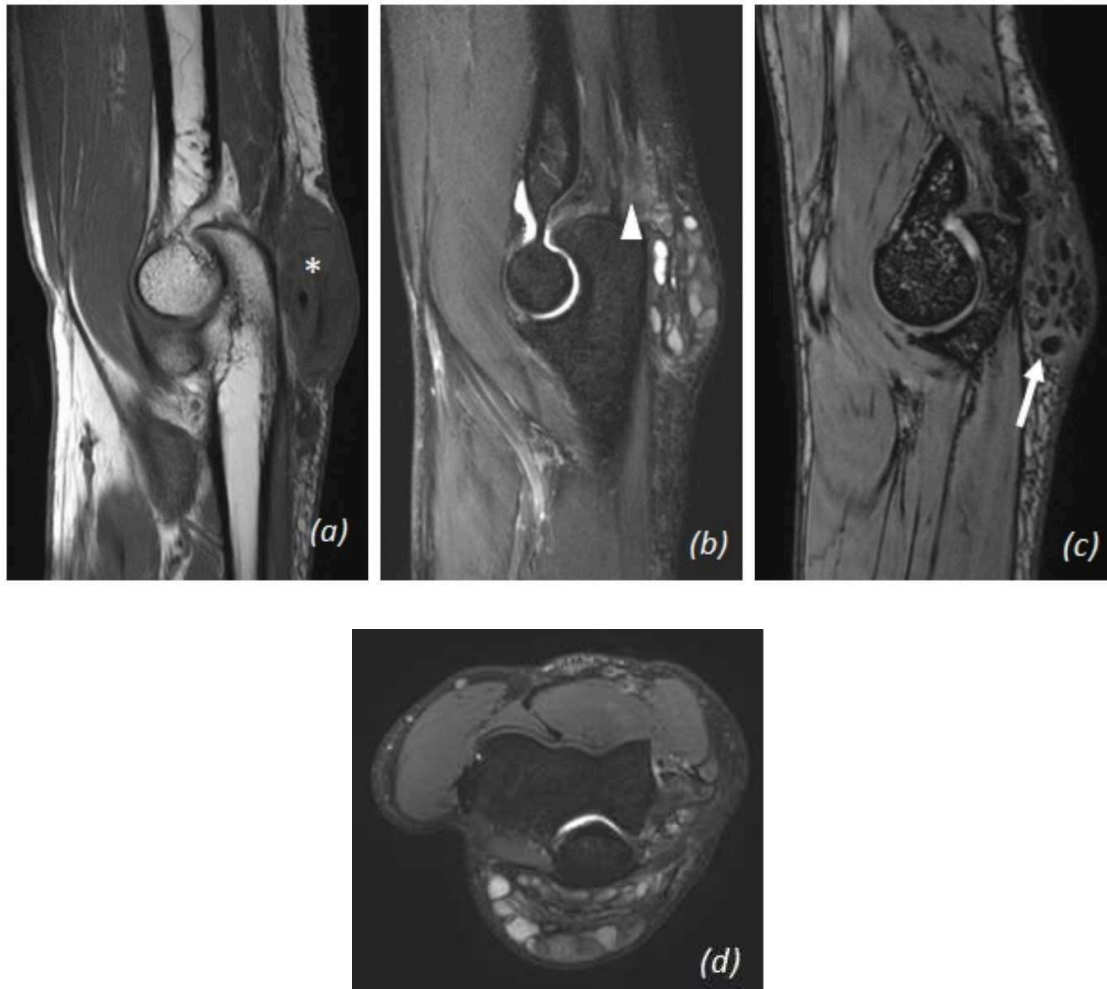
Magnetic Resonance Images of elbow-Sagittal (a) T1, (b) T2 FATSAT, (c) SWI images show multiple focal areas of blooming (arrow in (c)) within the distended bursa representing calcific foci. The inflammatory changes extend up to the insertional point of the triceps tendon, resulting in changes in tendinosis (arrowhead in (b)). No evidence of overt tear was noted. Axial (d) T2 FATSAT images showing distended olecranon bursae with multiloculated collections and calcific foci.
